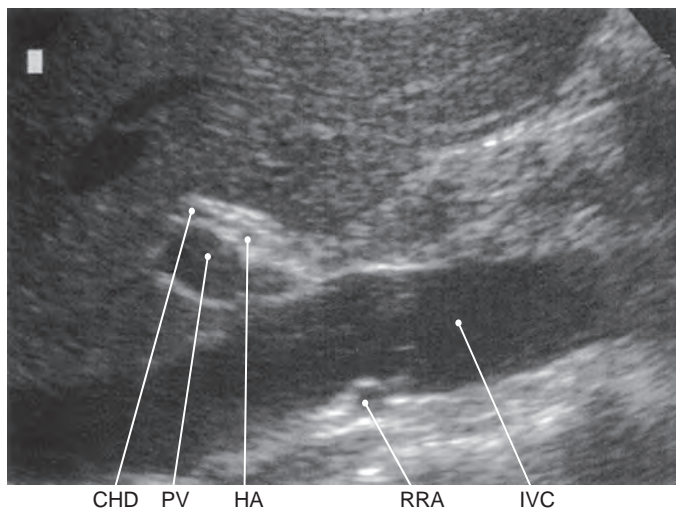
Porta hepatis. Oblique sagittal sonogram demonstrates a branch of the portal vein (PV), common hepatic duct (CHD), hepatic artery (HA), inferior vena cava (IVC), and right renal artery (RRA).
